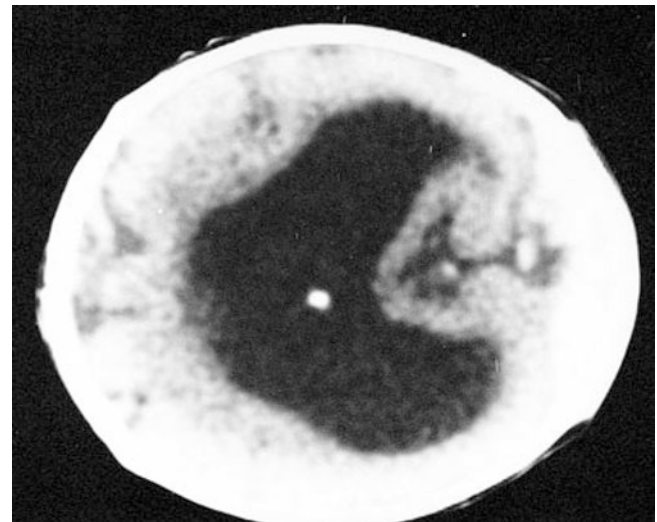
CT image of the head of an infant who presented with developmental delay, displaying semilobar holoprosencephaly. Note the incomplete differentiation of the two lateral ventricles and absence of the septum pellucidum. The interhemispheric fissure is rudimentary in its anterior aspect but is better developed in the occipital regions
